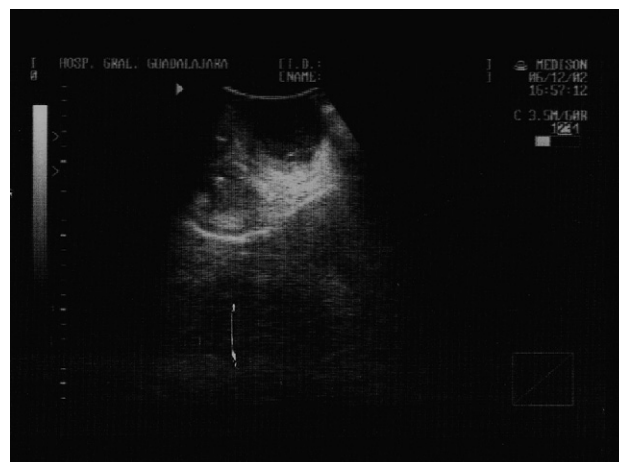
Testicular ultrasound showing heterogeneous content in both testes.
